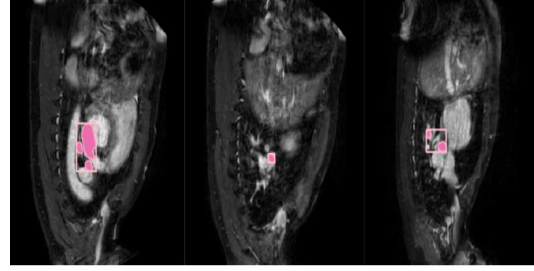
MR images from the Cardiac dataset with manual segmentation and bounding boxes segmentation overlaid on the left Atrium.
